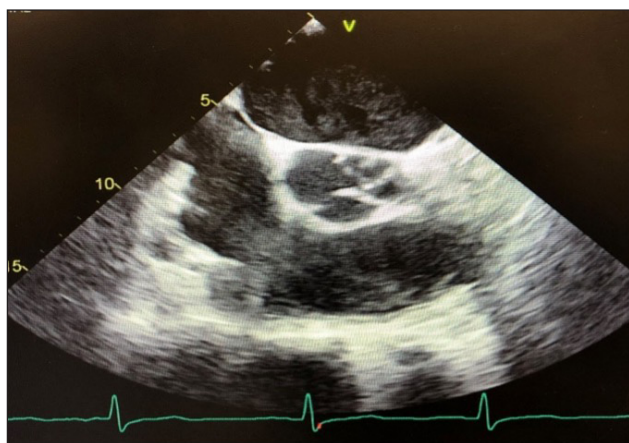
Post-COVID-19 transthoracic echocardiogram showing prolapse of the aortic valve leaflets during diastole.
